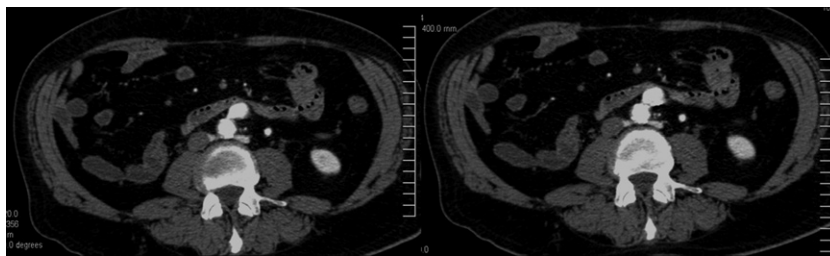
Preoperative CT scan demonstrating the atherosclerotic inferior mesenteric artery (IMA) aneurysm.
